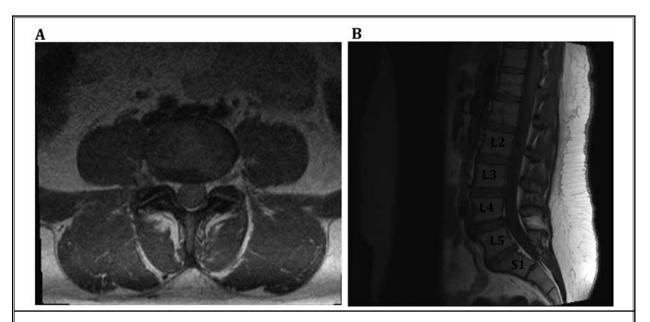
A: Axial image at L4 level of lumbar spine seen on T1 weighted MRI. Note slight narrowing of neural foramen on right side. B: Sagittal image of lumbar spine seen on T1 weighted MRI. Note disc protrusion at L4/5 interspace.
